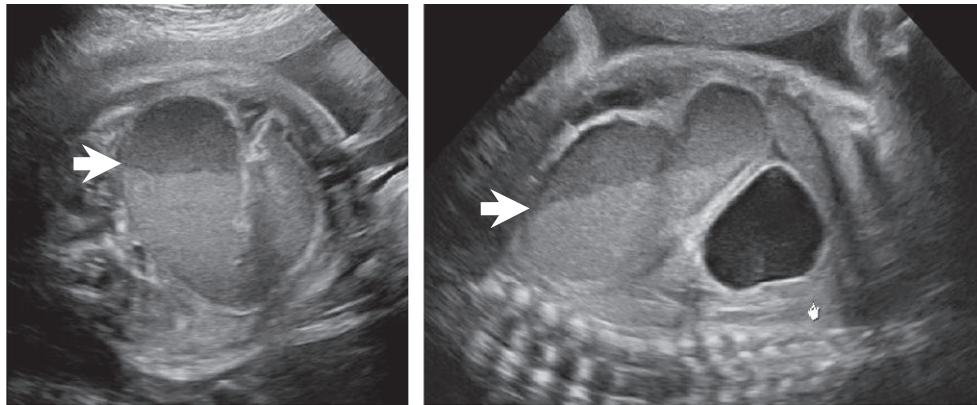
Case #3, 34 weeks of gestation. Prenatal midgut volvulus: Ultrasound features: fluid-filled level (→) (axial and parasagittal ultrasound images)
